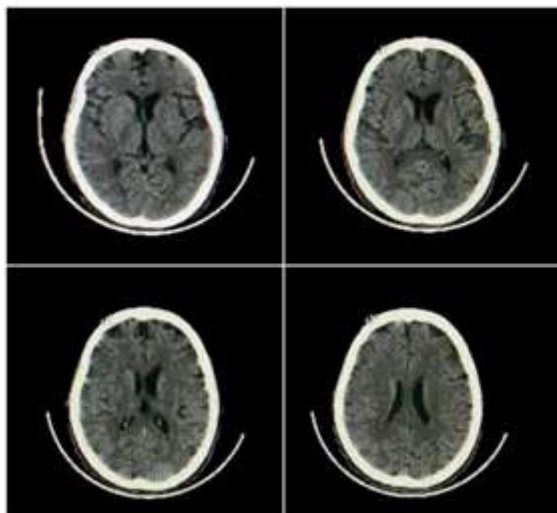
Head CT-Scan without contrast
